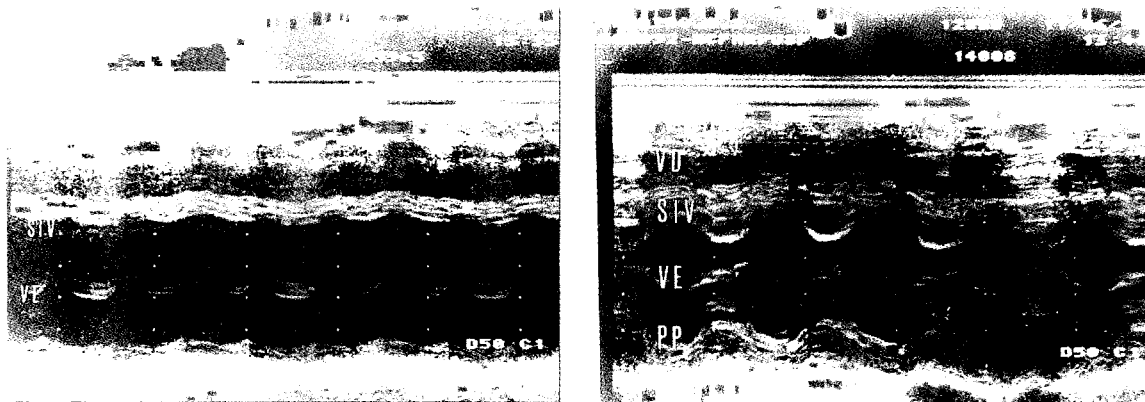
M-mode echocardiograms recorded in patient 4 at the level of the ventricles. A. 18 hours after sting by *T. serrulatus* showing severe hypokinesia of interventricular septum (SIV) and of the left ventricular posterior wall (PP). B. Return to a normal pattern 7 days after the sting.
